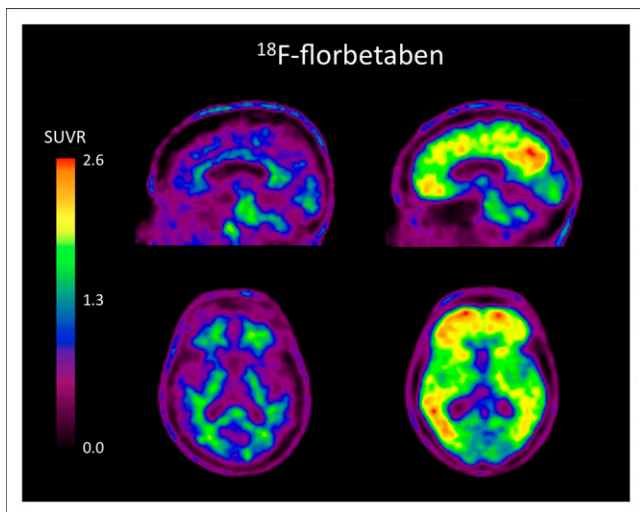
^{18}F -florbetaben images of 2 elderly subjects with MCI. Scan on left is negative for brain amyloid. Uptake in corpus callosum and pons is clearly seen on midsagittal image and only in white matter on transverse slice. This subject remained cognitively stable over 2 y of follow-up. Scan on right is positive for brain amyloid, with binding in frontal cortex, posterior cingulate gyrus, precuneus, and lateral temporal cortex. This subject progressed to AD over 2 y of follow-up. $\text{SUVR} = \text{SUV ratio}$.
